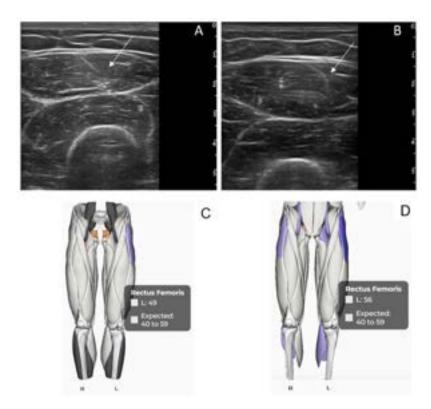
Apparent improvement in echogenicity due to growth. (A) Transverse ultrasound image of the right rectus femoris on baseline in a 17-year-old female patient with FSHD. (B) Same muscle in the same patient at 5-year follow-up (age 22). (C) An apparent improvement in echogenicity measured with ultrasound (panels A and B) is observed, which is likely related to normal growth. The increase in muscle volume changed the relative proportion of fascia (hyperechoic; white) and muscle tissue (hypoechoic; black). (D) Springbok Muscle MRI image showing left rectus femoris muscle volume at baseline in a 19-year-old male with mild FSHD. (E) Same muscle showing increased muscle volume at 12-months follow-up (age 20).
